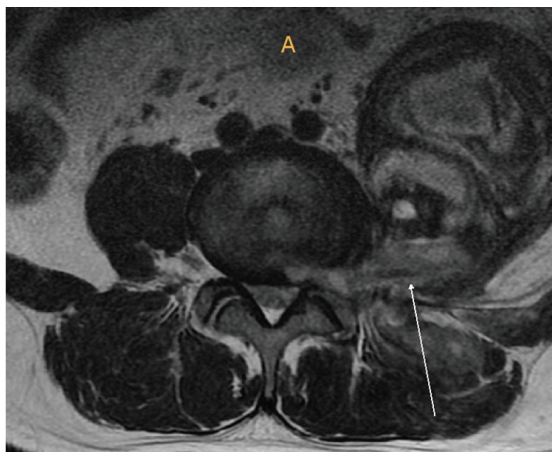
Lumbar spine contrast-enhanced MRI T2 weighted image on next day after embolization revealed a huge hematoma in the left psoas muscle encasing left L4 nerve root (arrows).
